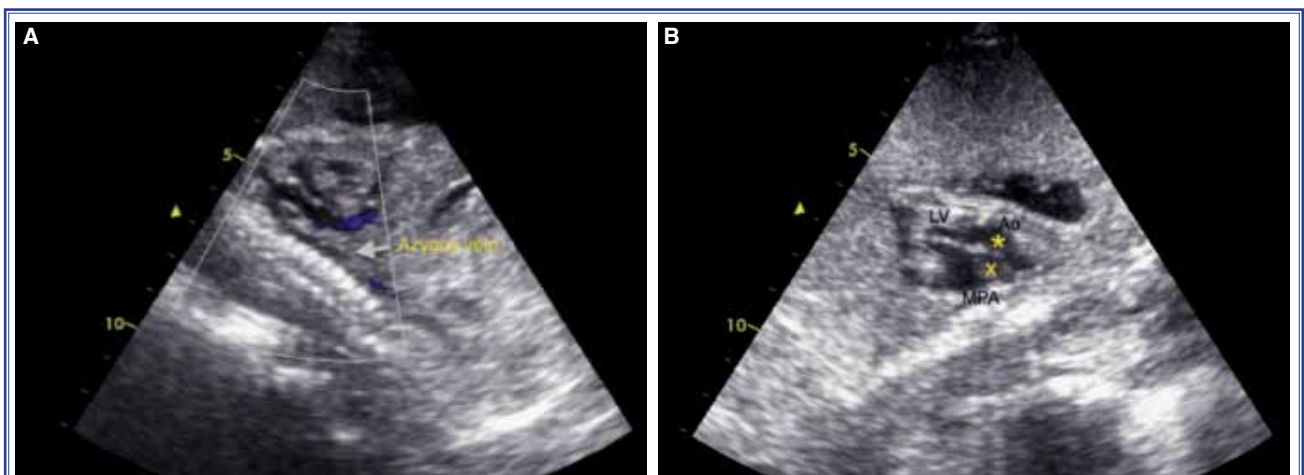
(A) Sagittal view of the chest demonstrating the azygos vein posterior to the aorta. (B) Echocardiographic view demonstrating the main pulmonary artery (MPA) and aorta (Ao) arising from the left ventricle (LV).
